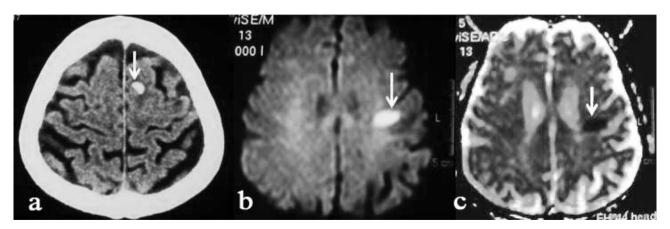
The CT scan of the brain reveals a) a hemorrhage in the superior frontal gyrus of the left hemisphere. The MRI diffusion images b) and c) also reveal an acute infarct in the lower part of the primary motor cortex at the junction between the cortex and white matter.
